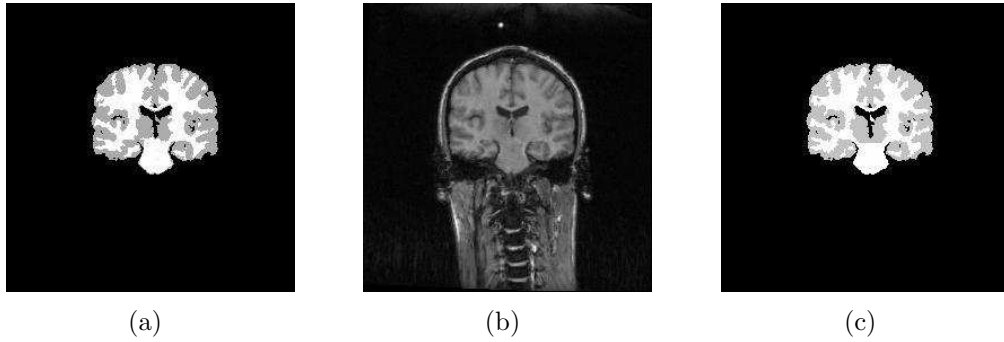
Segmentation of WM and GM tissues by our proposed method (Fig. 3.6(a)) on a real T1-weighted MRI image from ISBR (Fig. 3.6(b)) and its expert hand segmentation (Fig. 3.6(c)).
